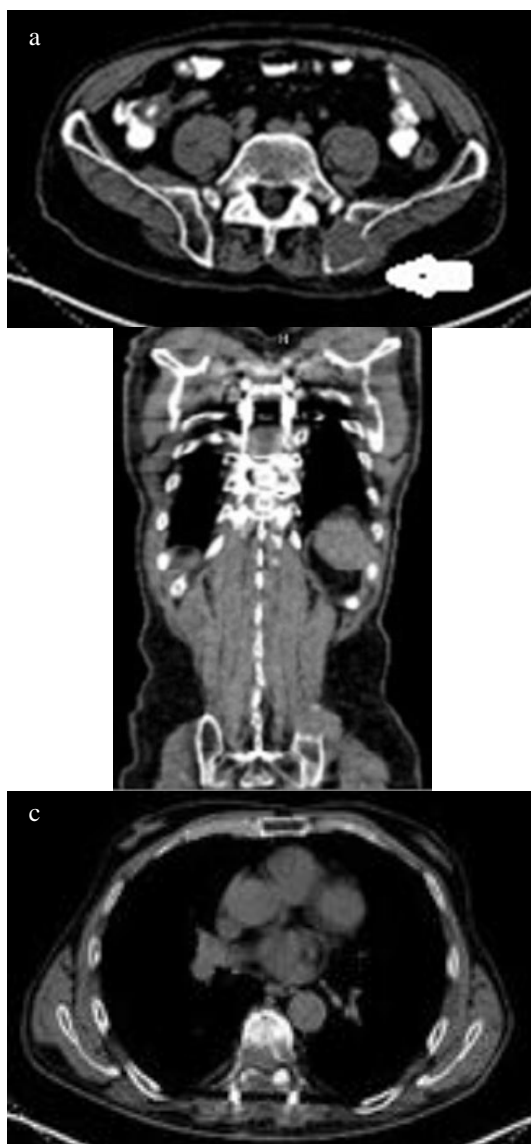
PET-CT images at month-20 after surgery. Note the 39 mm metastatic lesion at the left sacroiliac joint (arrow; a, b) and the intact T7 vertebra (c)
